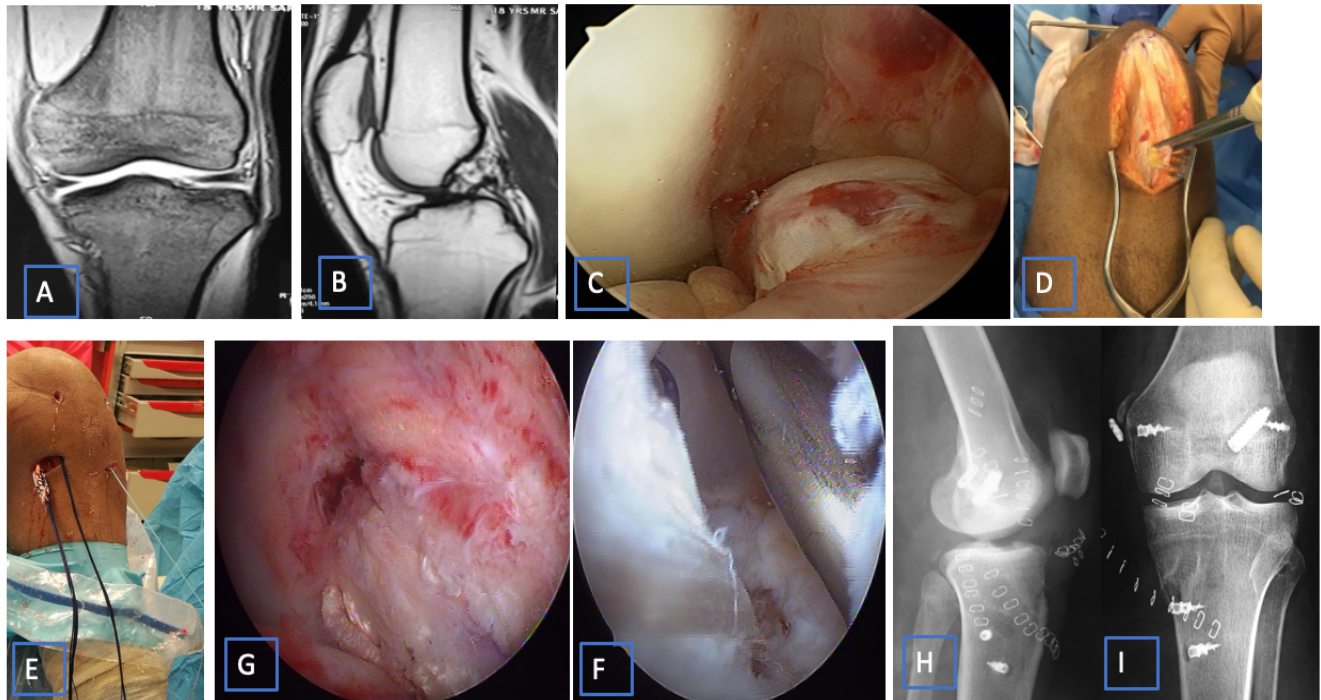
A. Coronal view Knee MRI showing MCL Tear B. Sagittal view Knee MRI showing torn ACL C. Arthroscopic view showing torn ACL D. Contralateral Quadriceps tendon Graft harvested E. Ipsilateral Hamstring tendon harvested F. Passing for Quadricep tendon graft through tunnel for ACL reconstruction G. Hamstring Graft passing through tunnel for PCL reconstruction H. Post – Operative X – ray shows well placed grafts fixed with endobutton and interferential screw.
